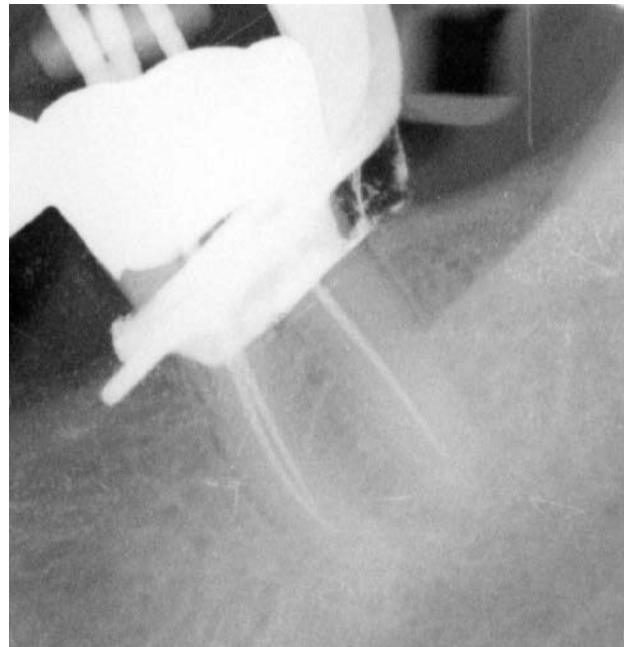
Figure Fig: 8-2: Radiographic confirmation of the root canal length.
